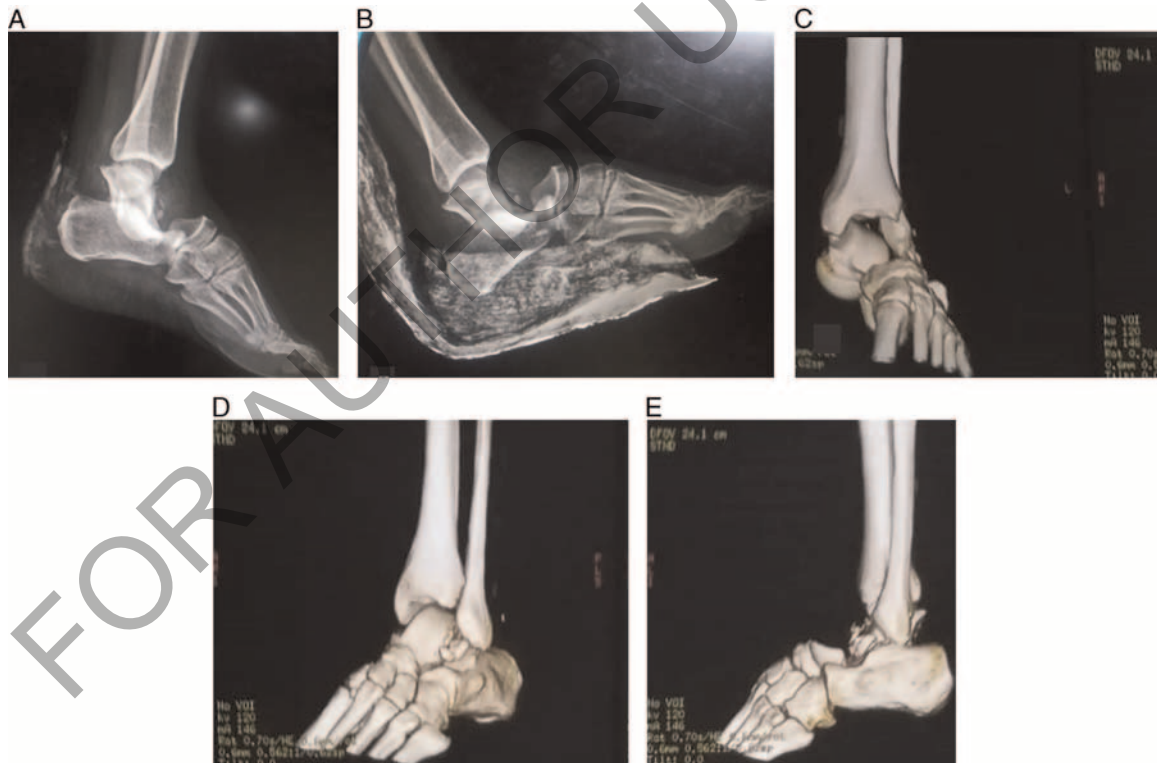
Preoperative radiographs (A and B) and preoperative CT scans (C, D, and E) of failure of closed reduction.
